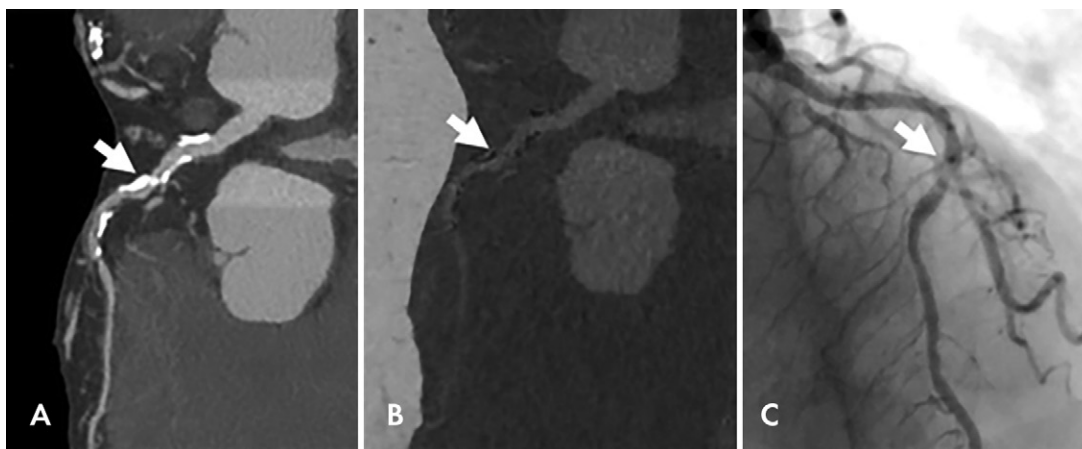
Images in a 92-year-old woman with chest pain. A, Dual-energy coronary CT angiogram. B, Material decomposition–based calcium suppression and, C, corresponding invasive coronary angiogram show a patent lumen visualized with calcium suppression imaging. Arrow indicates the same middle left anterior descending coronary lesion. (Reprinted, with permission, from reference 63.)
